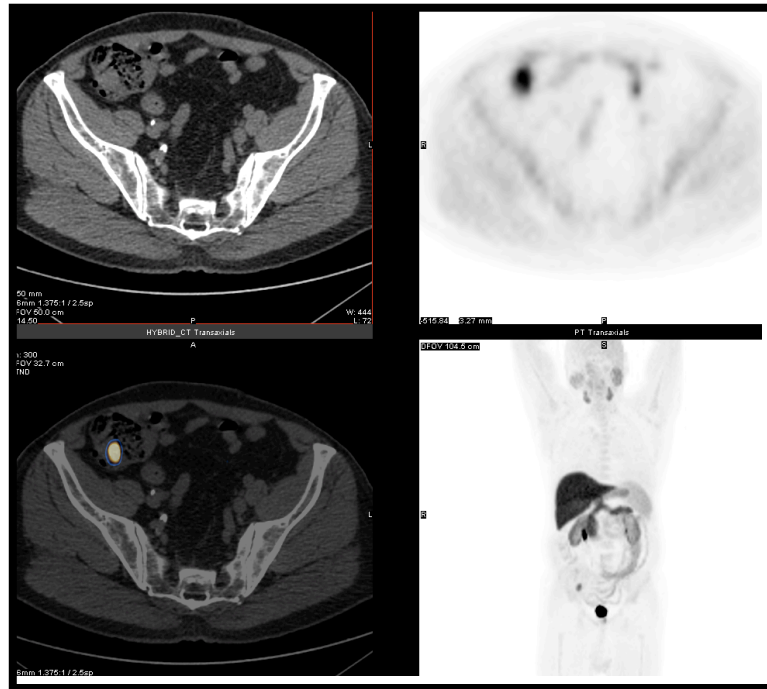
As choline activity is lacking in the distal part of the small bowel (unlike with ^{18}F FDG, where uptake in the ileo-caecal region is normal variant), any evidence of choline kinase activity should be considered cautiously in this region. Note that in this case there is focal uptake with ^{18}F Ethyl Choline in the caecum which was confirmed with biopsy to be tubule-villous adenoma.
